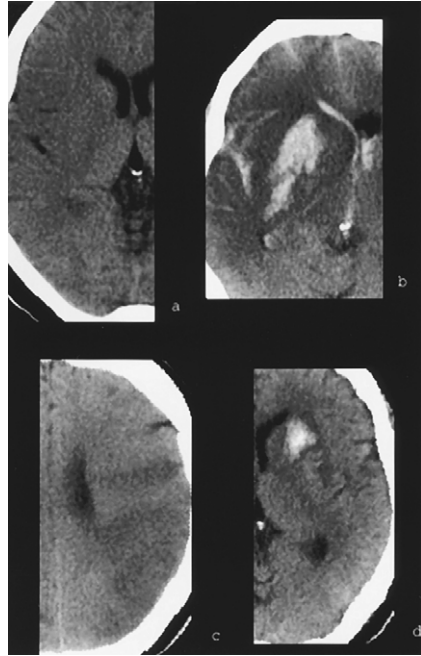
Hemorrhagic infarct. (a) Right middle cerebral artery (MCA) territory acute infarct. (b) Putaminal hemorrhage identified on the next day was associated with neurologic deterioration. (d) In another patient with a clinical left MCA territory infarct, CT showed a left putaminal hematoma but no sign of an infarct. Follow-up study shows a frontoparietal infarct.
